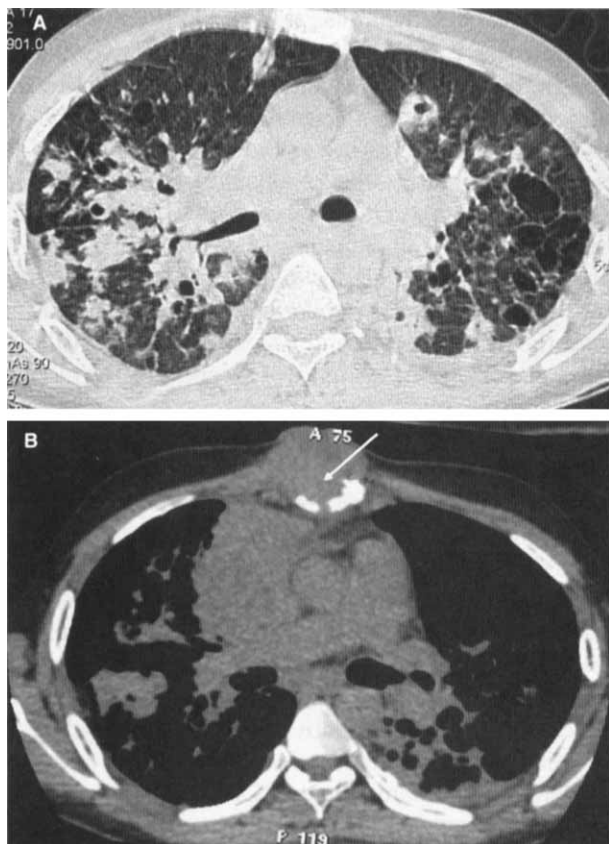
Top, A:* CT scan of the chest demonstrating bilateral bronchiectasis. *Bottom, B:* CT scan of the chest demonstrating sternal osteomyelitis (arrow).
